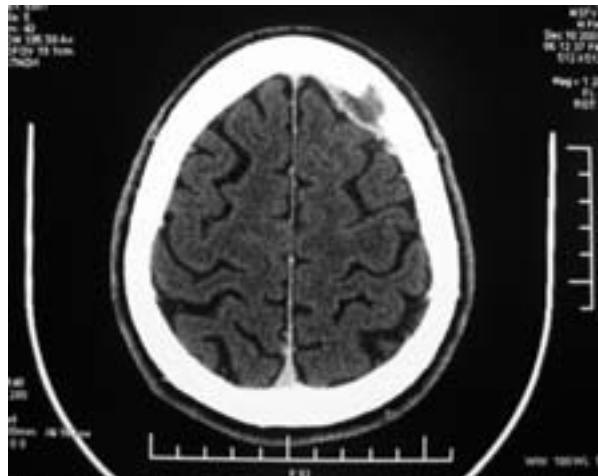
Computed tomography scan of the head showing a 4x1.5-cm left epidural lentiform hypodensity with an adjacent frontal bone defect.
